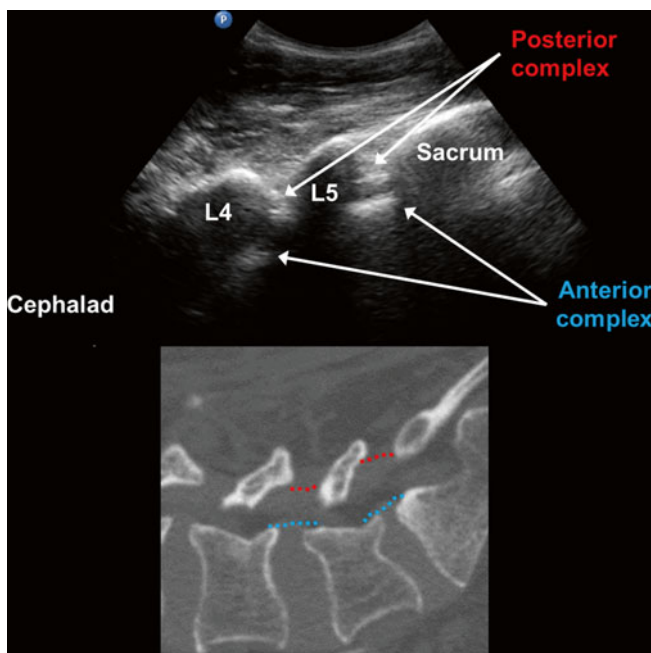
Parasagittal oblique view of the L5–S1 junction and corresponding computed tomography image (*below*). The sacrum is recognizable as a horizontal hyperechoic linear structure, and the L5 lamina has the typical “sawtooth” appearance. The posterior and anterior complexes are visible through the intervening gap (Courtesy of www.usra.ca)
